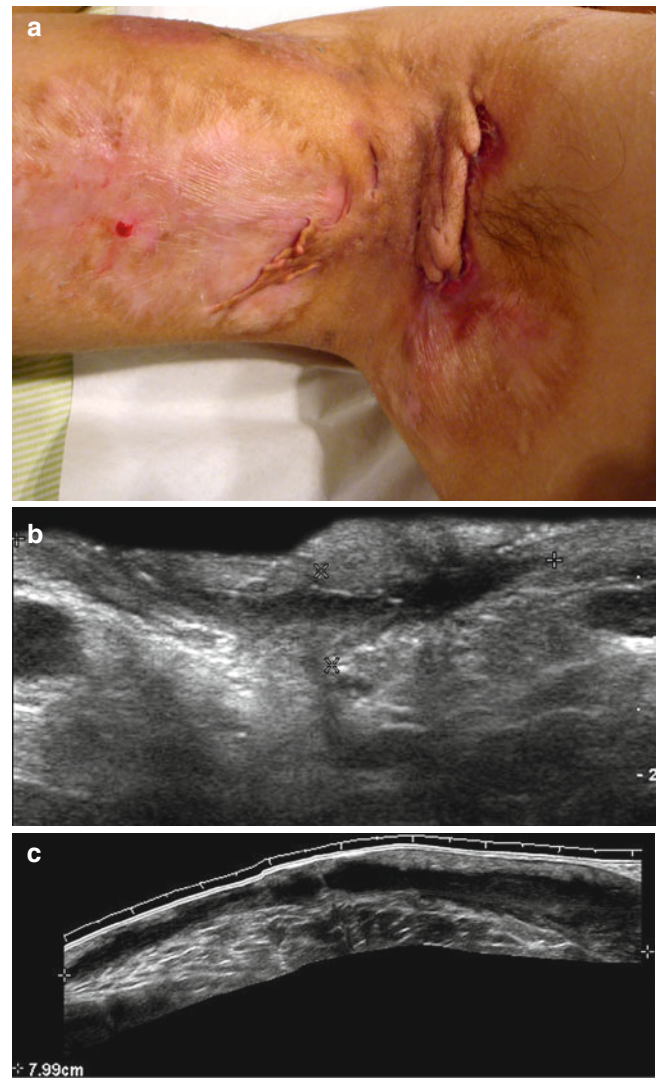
(a–c) Hidradenitis suppurativa. (a) Clinical image shows extensive scarring, erythema and bumps in the right axilla (Hurley III). (b) Gray scale ultrasound image (transverse view) demonstrates one of the several hypoechoic fistulous tracts (between markers). (c) Gray scale extended field of view (longitudinal view) shows a 7.99 cm long hypoechoic fistulous tract (between markers) located in dermis and subcutaneous tissue in the same patient
